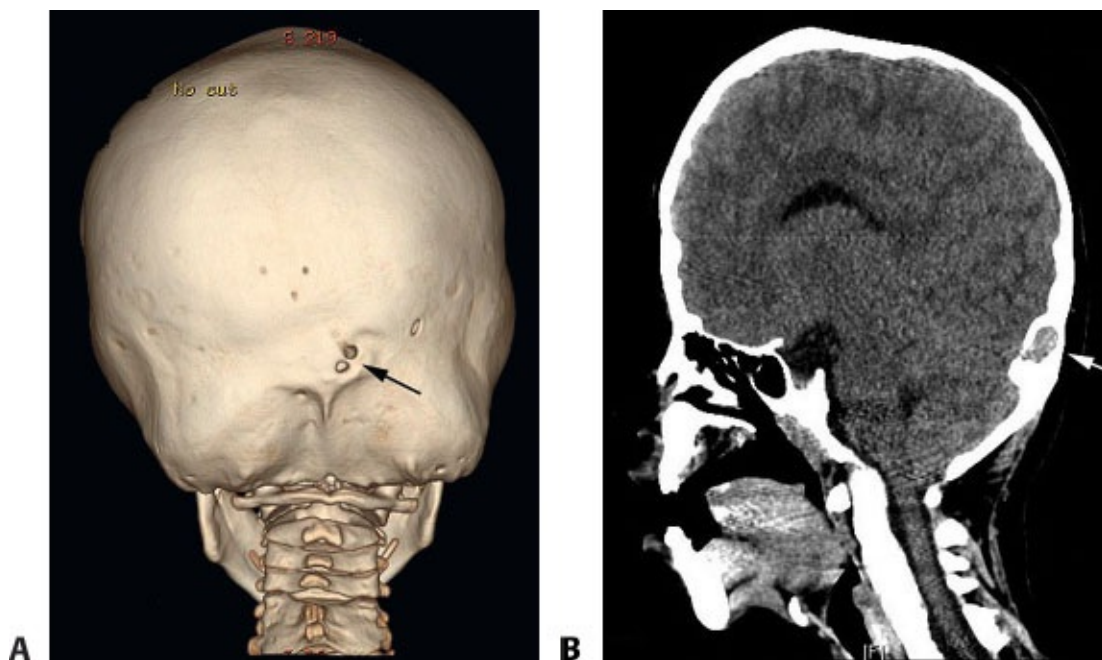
• A patient with Apert syndrome prior to posterior vault distraction. A. A circular defect (*arrow*) in the posterior calvarium was suggestive of anomalous transcranial venous drainage. B. The communication between scalp and transverse sinus was confirmed on sagittal view (*arrow*) and on MRI with contrast. To avoid
